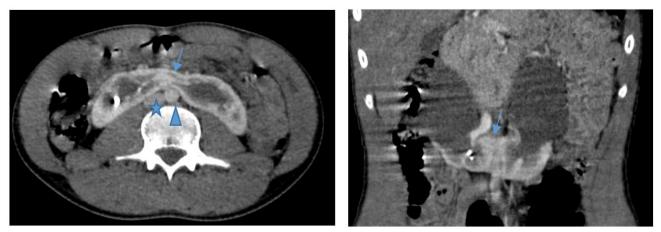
Computed tomography (CT): axial and coronal plans scan revealed kidneys fused by their lower poles (arrow) in front of the aorta (arrowhead) and inferior vena cava (asterisk)
